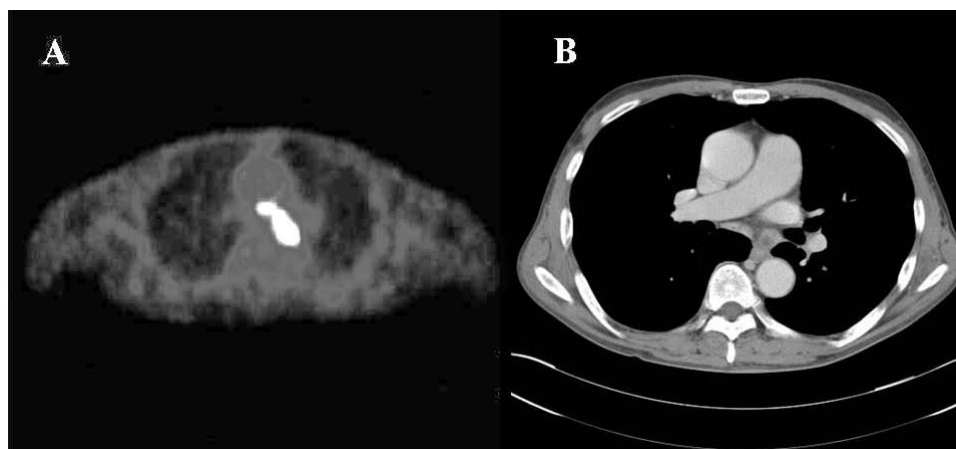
A) Positron emission tomography (PET)/computed tomography (CT) scan reveals focal hot uptaking lesions in the mediastinum, B) conventional chest CT scan is taken and reveals a well-enhancing soft tissue lesion with internal low density areas are noted in the mediastinum including the subcarinal area.
